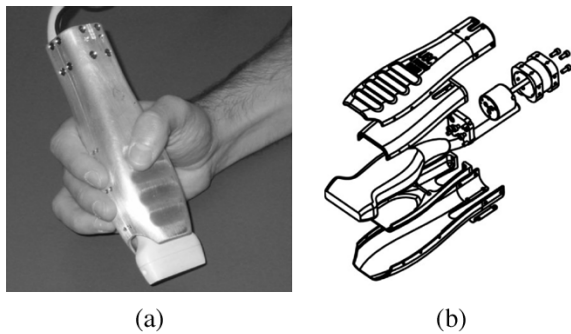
Sensorized ultrasound probe used in the DVT screening system shown, with (a) examiner grasping the outer shell which surrounds the ultrasound probe itself, (b) an inner shell and a force/torque sensor.
